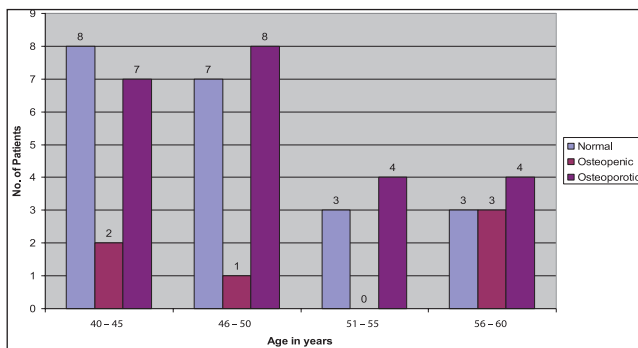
Age-wise distribution of normal, osteopenic and osteoporotic patients who were confirmed with BMD, which was performed using quantitative ultrasound
